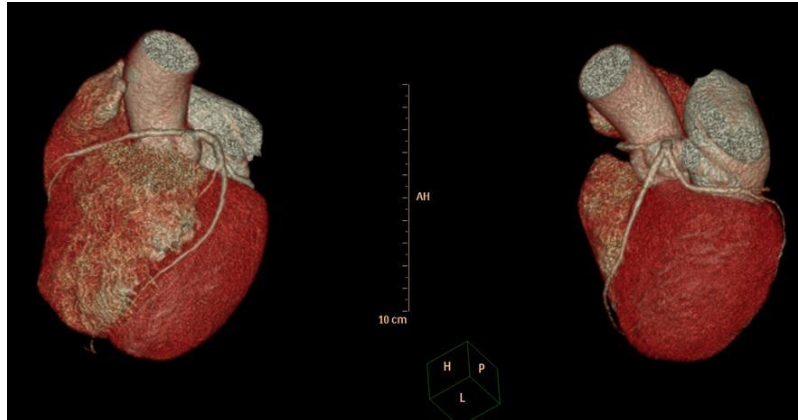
Coronary computed tomography angiography tridimensional reconstruction showing the right coronary artery emerging from the left Valsalva sinus. Notice the right ventricle outflow tract anteriorly to the right coronary artery (Pulmonary artery removed)
